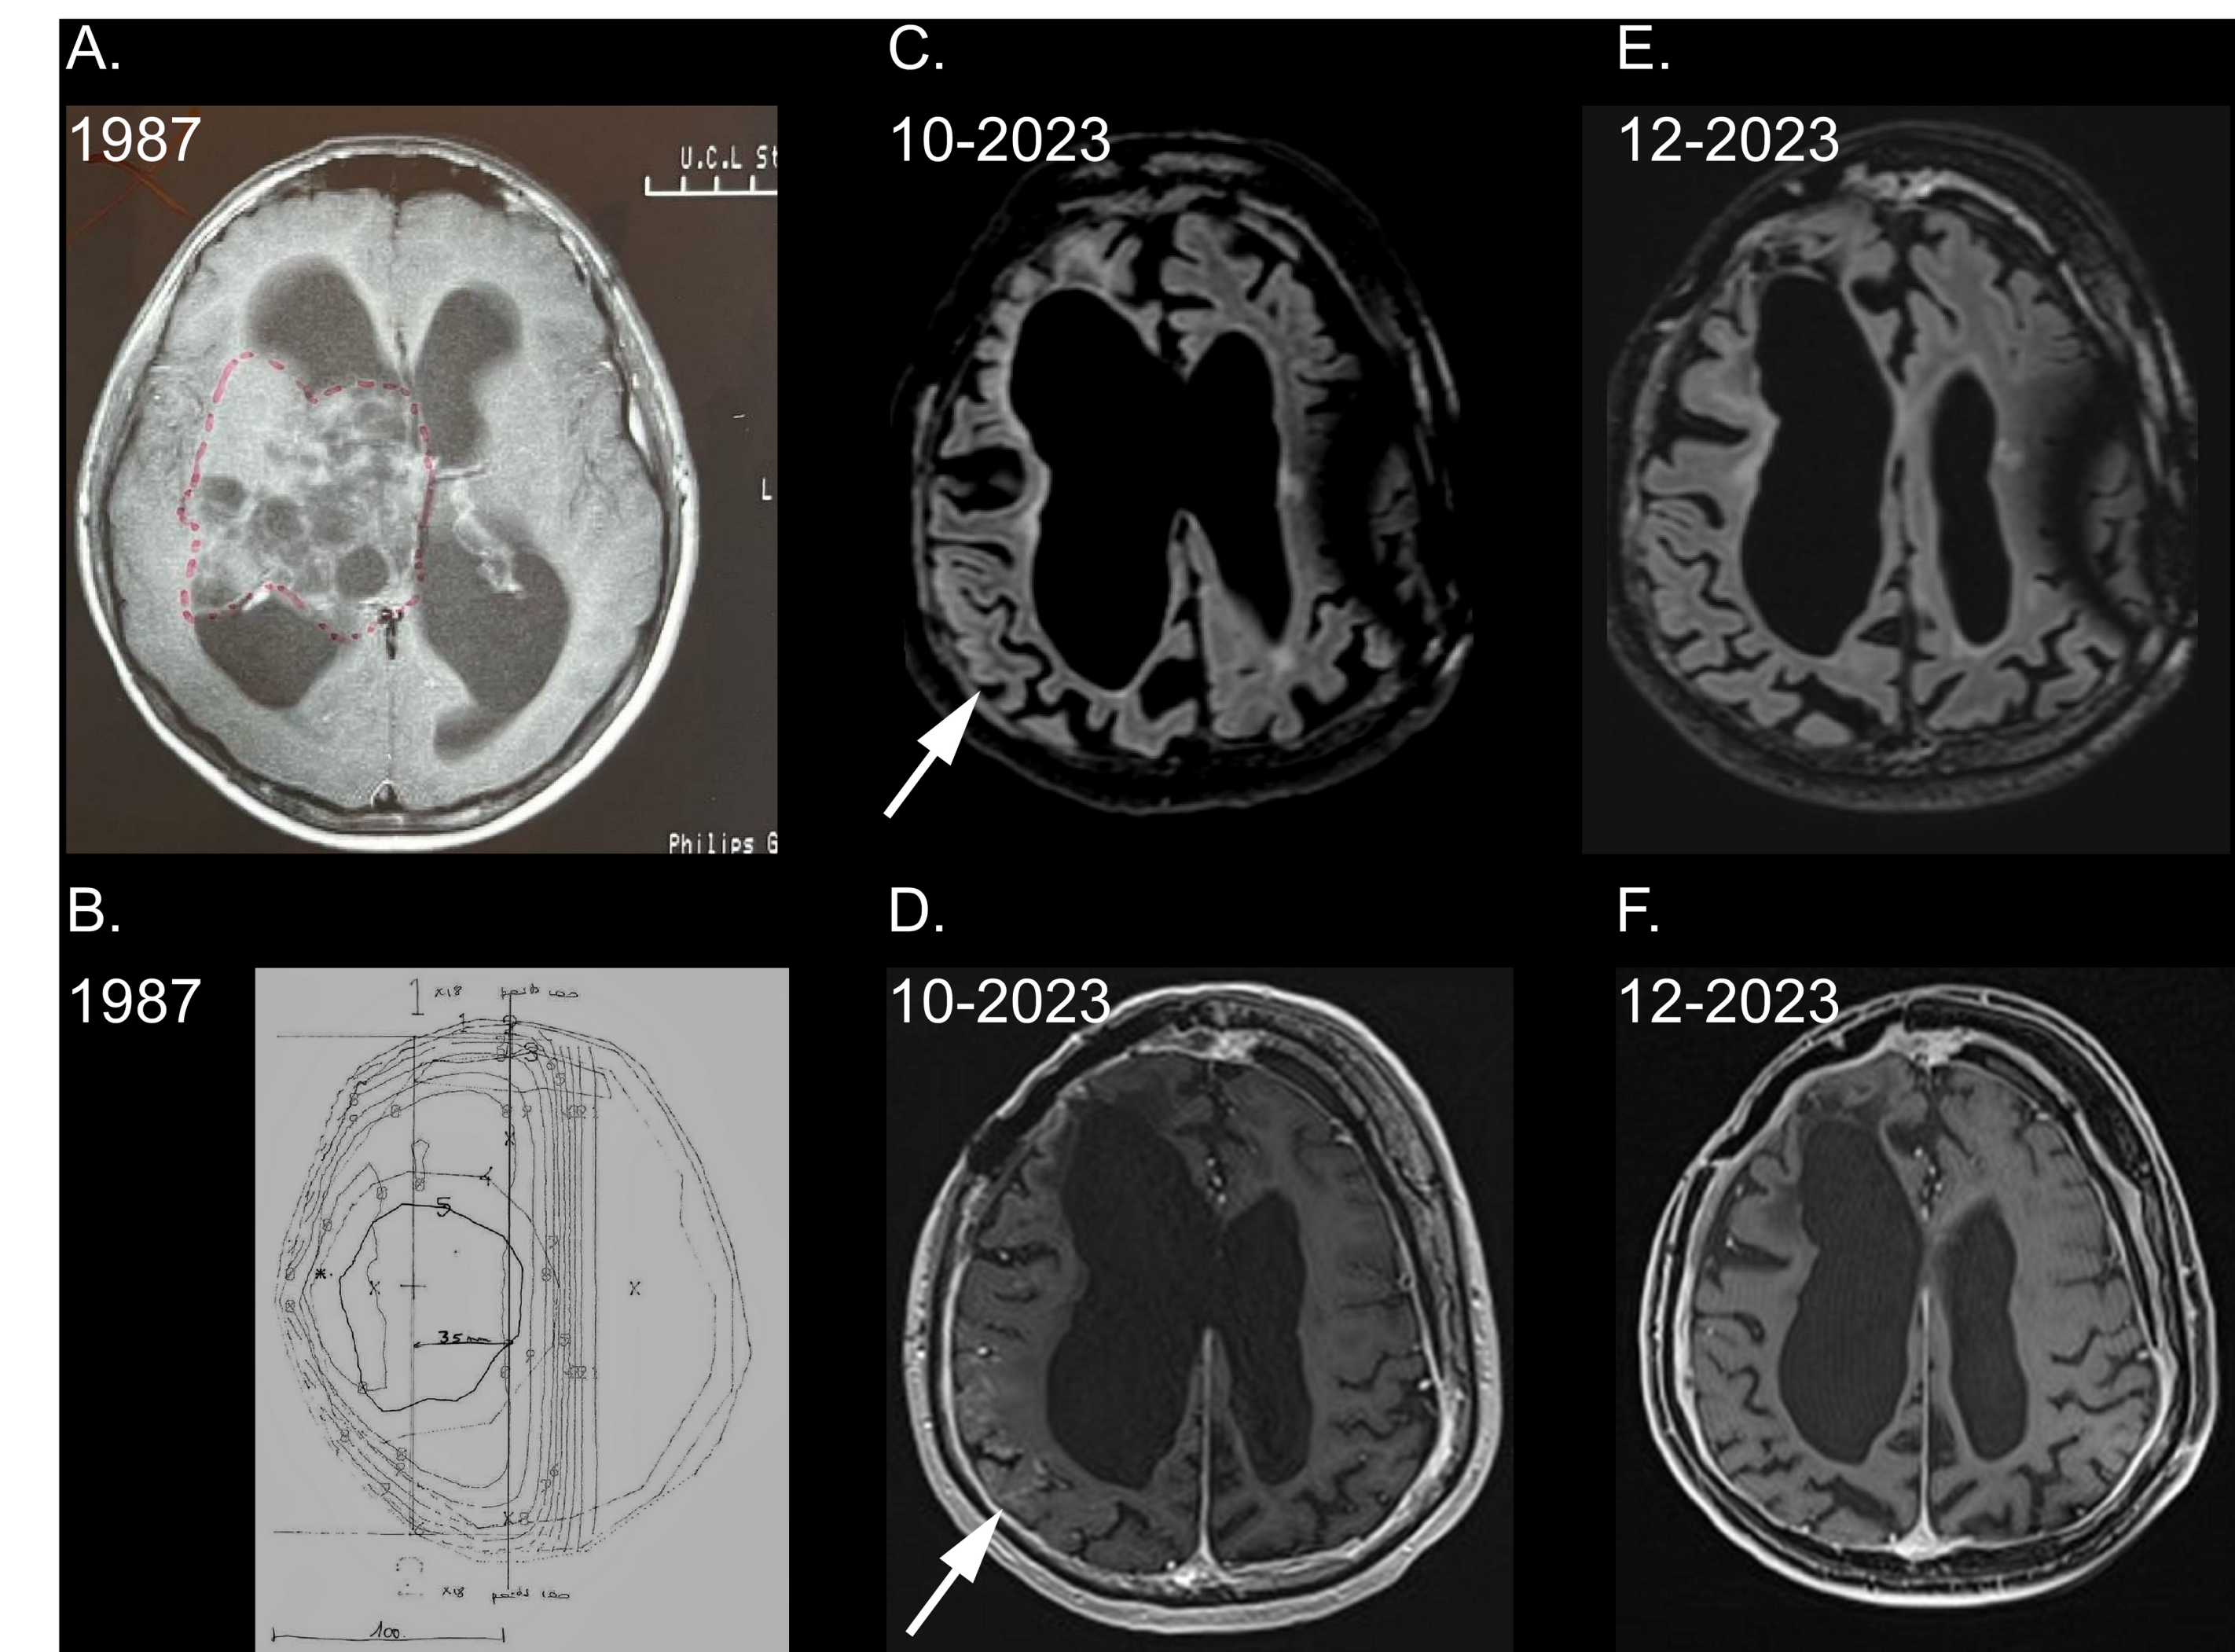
T1 MRI sequence showing the tumour at the time of diagnosis (1987). B. Radiation dose distribution for the 24-Gy sequential boost (1987). C. T2 FLAIR MRI sequence showing hyperintensity of right parieto-occipital cortex (10-2023). D. T1 post-gadolinium sequence showing gyral enhancement (10-2023). E. T2 FLAIR MRI sequence showing vanishing of the hyperintensity of the right parieto-occipital cortex (12-2023). F. T1 post-gadolinium sequence showing disappearance of the gyral enhancement (12-2023).
